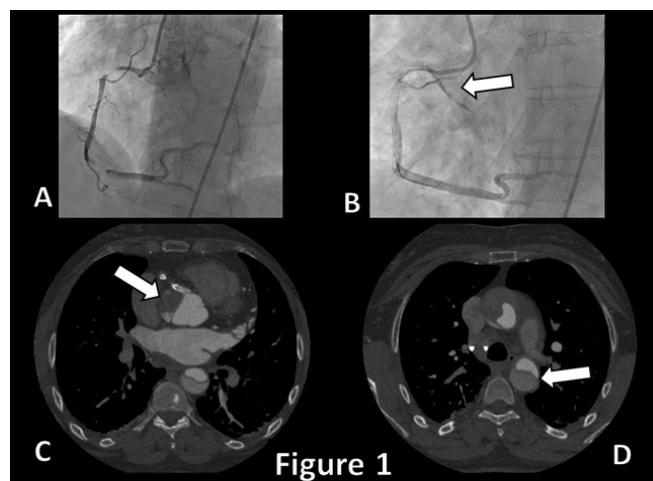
Coronary angiogram showing multiple stenosis on the right coronary artery and the evidence of aortic wall dissection after stenting (A & B, arrow). Axial thoracic computed tomography view showing the type A aortic dissection progressing to the descending aorta (C & D, arrows).
